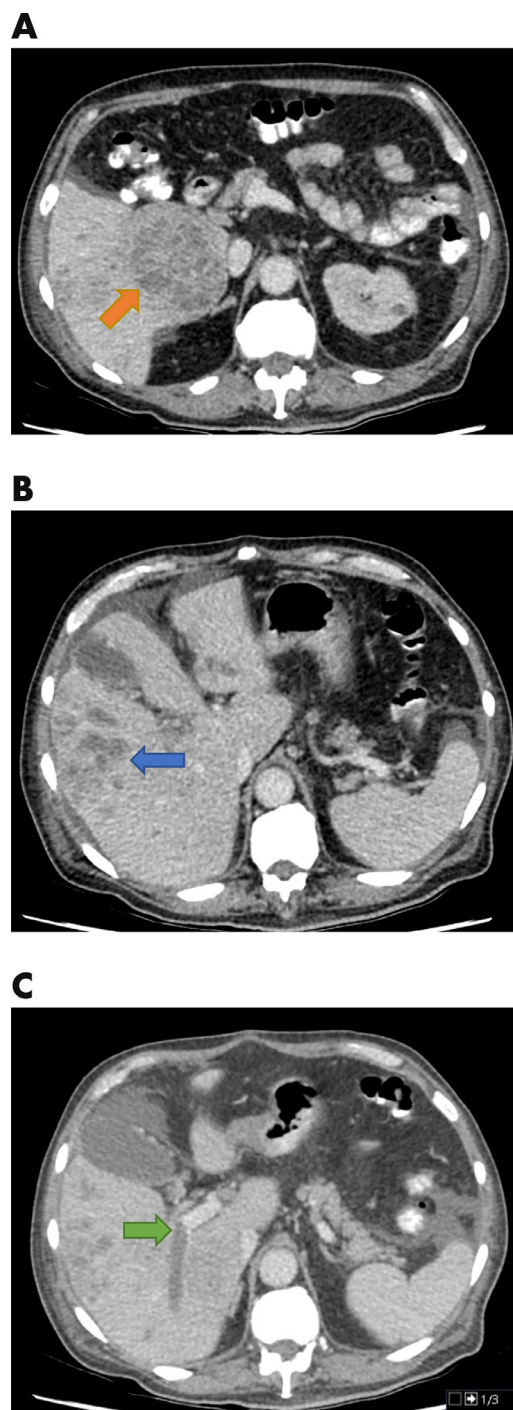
(A) Axial CT abdomen image after administration of intravenous iodinated contrast in portal venous phase showing a large ill-defined mass-like region of heterogeneous low density in hepatic segments 5 and 6 measuring approximately $7.5 \times 6.3 \times 8.0$ cm, extending to the hilar region (orange arrow). (B) Wedge-shaped heterogeneous density lesion involving segment 8 (blue arrow). (C) Thrombus within the right portal vein (green arrow).
